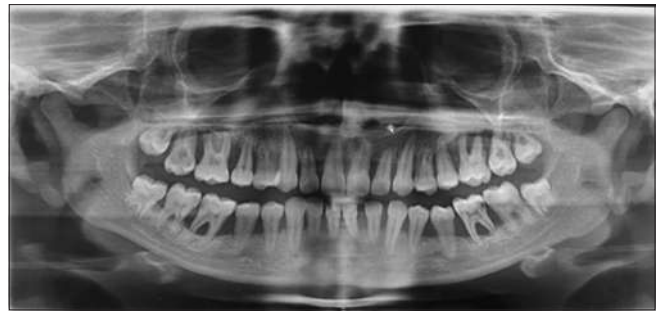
Panoramic radiograph reveals generalized horizontal bone loss
